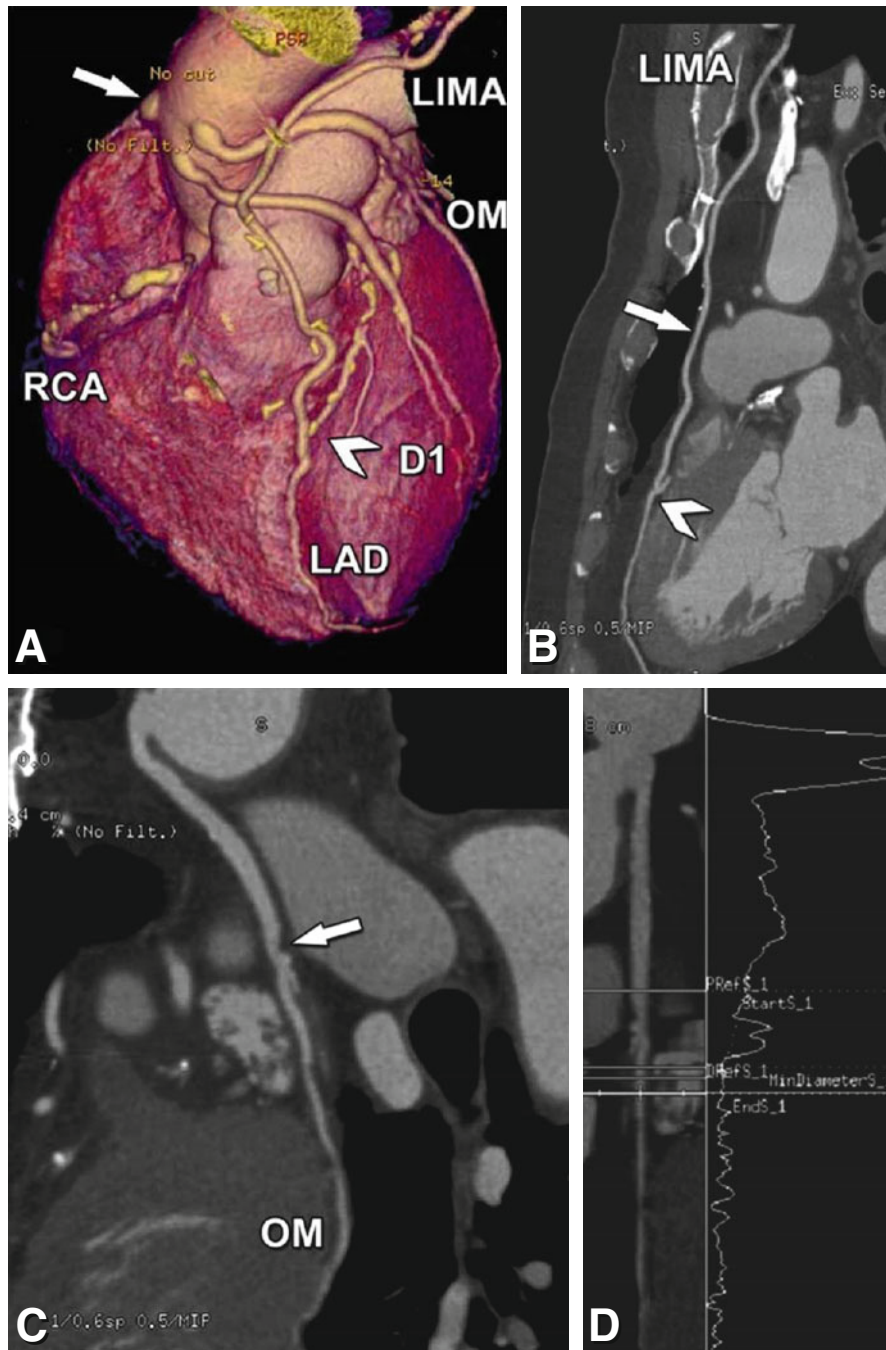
64-year-old male patient who was underwent left internal mammary artery (LIMA, skeletonized) grafting to the left descending coronary artery and vein grafts to the right coronary artery (RCA), the diagonal branch (D1), and to the obtuse marginal branch (OM, Panel A, three-dimensional reconstruction) 14 years ago. CT was performed because of an inferior myocardial perfusion defect on single-photon emission computed tomography. The skeletonized LIMA graft is patent (arrow in Panel B, curved multiplanar reformation) with a normal distal anastomosis (arrowhead in Panels A and B) but the vein graft to the RCA is occluded (arrow in Panel A). The venous graft to the OM branch shows luminal narrowing (arrow in Panel C, curved multiplanar reformation), which was estimated to be not significant by quantitative analysis (14% diameter stenosis in Panel D, lumen stripe reformation)
